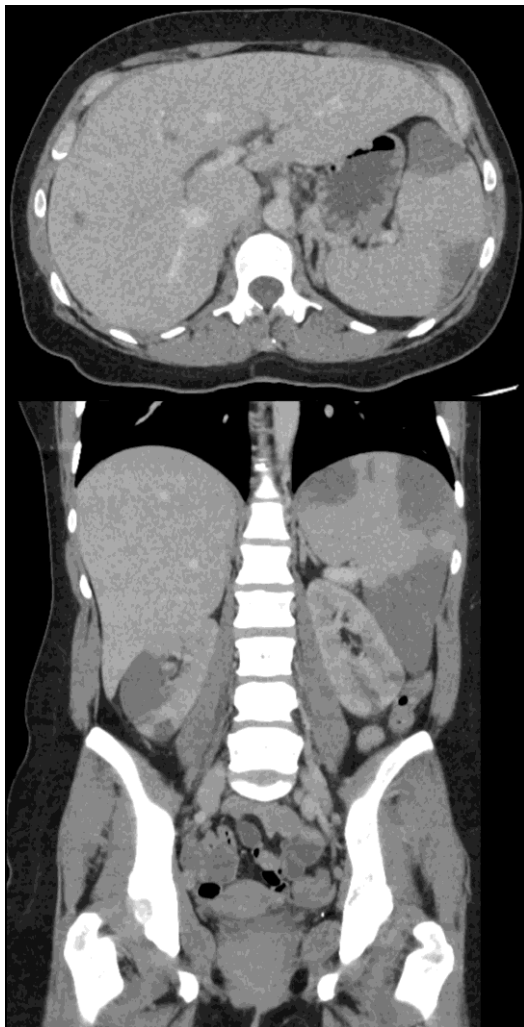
Axial and coronal images of initial CT scan showing splenic and renal infarcts.
